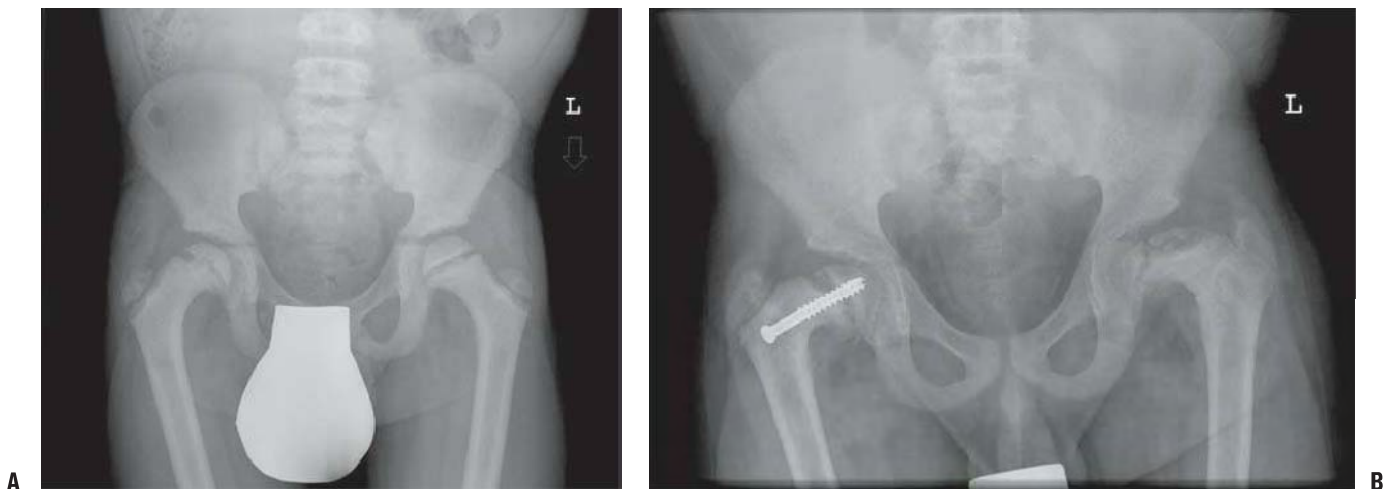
Renal osteodystrophy in a 12-year-old boy. A: An anteroposterior pelvis x-ray reveals an early capital femoral epiphysis on the right. Slipped capital femoral epiphysis is common in renal osteodystrophy and rare in rickets. B: Three years after fixation the right proximal femoral epiphysis remains open and stable; the left hip now shows signs of epiphyseal avascular necrosis and fragmentation.
